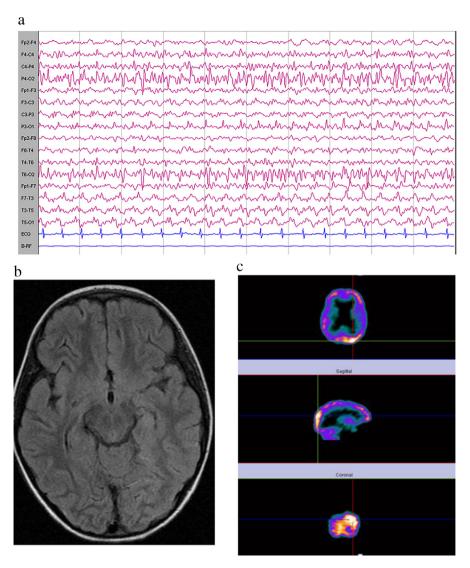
(a). EEG: left parietal-occipital continuous paroxysmal activity. (b). MRI (day 41): T2/FLAIR sequence — slight hyperintensity and thickening of the left temporal-occipital cortex. (c). Ictal SPECT (injection 2 s after seizure onset, 99 mTc-ECD): left occipital hyperperfusion. The ictal EEG showed a left occipital focus, with subsequent spread to adjacent regions.
